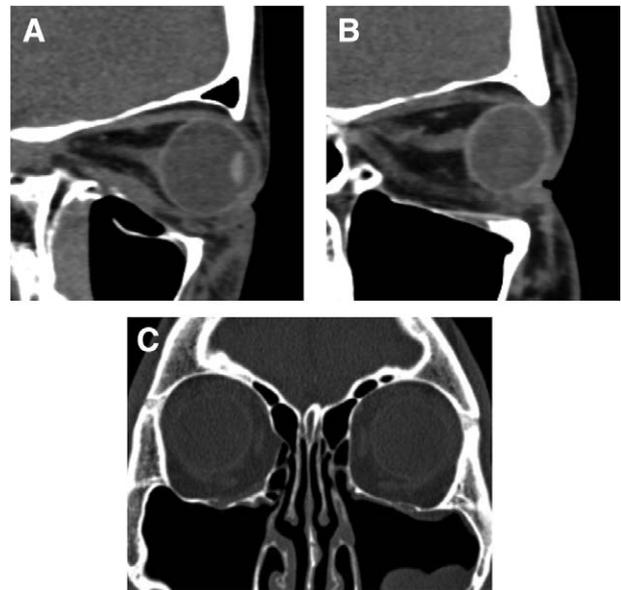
Bioresorbable implants are radiologically visible especially in the early postoperative period. A, Early postoperative imaging was performed for this patient with a bioresorbable implant; the bioresorbable implant is clearly seen on the CT scan. This confirms the accurate placement of the implant. B, This patient experienced upgaze restriction at postoperative month 6. A CT scan was performed that showed a (poly-L/DL-lactide) 85/15 implant that was inappropriately small and not resting on the posterior ledge. The ability to visualize the implant on CT scan enables the surgeon to correlate the patient's symptoms with implant placement. C, Late postoperative imaging showing good reduction and neobone formation with complete resorption of bioresorbable implant (right eye).
